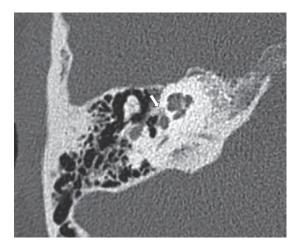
High resolution CT scan, with a focus of antefenestral otospongiosis marked with an arrow, in a patient who had subsequent successful stapes surgery.
